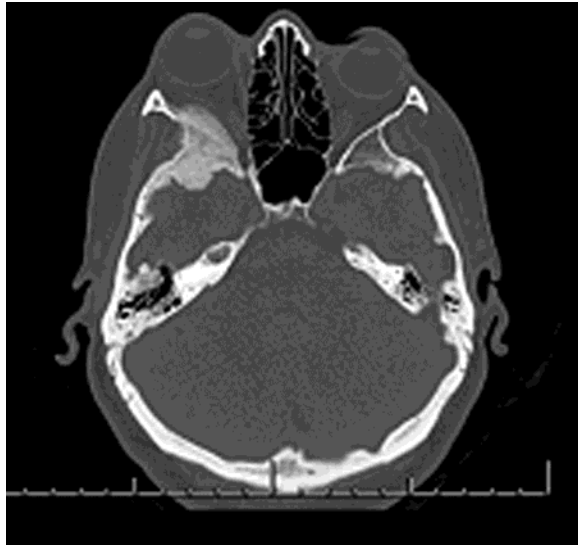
Axial computed tomography scan (bone window) showing the extent of the largely intraosseous meningioma involving the right sphenoid wing and causing proptosis of the right eye
